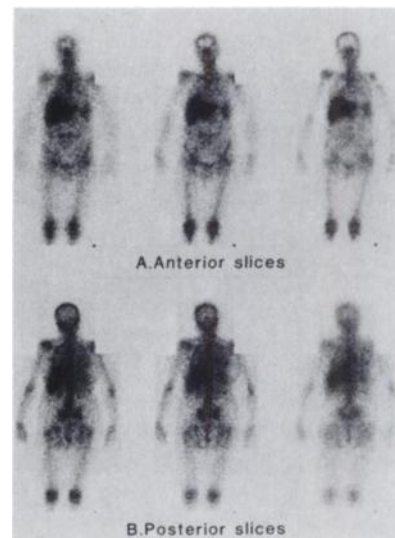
Tomographic scintigrams obtained with same scanner at day 3 after Ga-67 citrate. The scan simply reflects increased bony activity.
